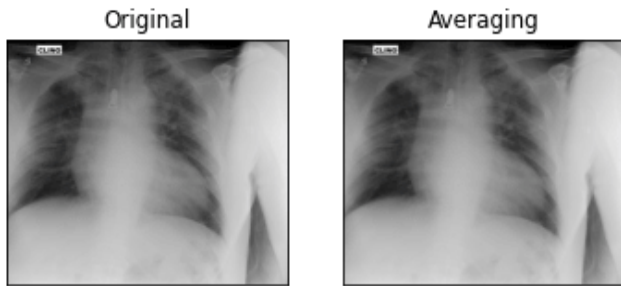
(c). Outputs of second X-Ray image before and after filtering it using Mean Filter
